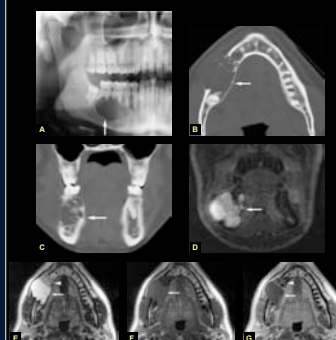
Ameloblastoma, unilocular, mandible: 22-year-old male with painless paranasal swelling. A: Painless, slow swelling of lower lip and lower mandible. B: Axial CT image shows well-defined bone with expansion of buccal cortical bone, which is very thin and partially absent (arrow). C: Coronal CT image shows multilocular appearance in inferior part (arrow) and cortical outline (arrow). D: Coronal MRI image shows multilocular appearance and heterogeneous intermediate to high signal (arrow). E: Axial T2-weighted MRI shows high signal in posterior part (arrow) and intermediate signal in anterior part (arrow). F: Axial T1-weighted pre-contrast MRI shows low intermediate signal in posterior part (arrow) and high signal in anterior part (arrow). G: Axial T2-weighted post-contrast MRI shows no contrast enhancement in posterior part (arrow) except papillary and septal enhancement in anterior part (arrowhead).
